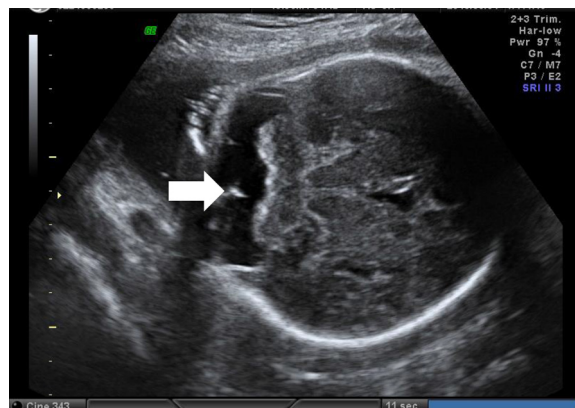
Fetal ultrasonography showed enlarged posterior fossa (white arrow).
